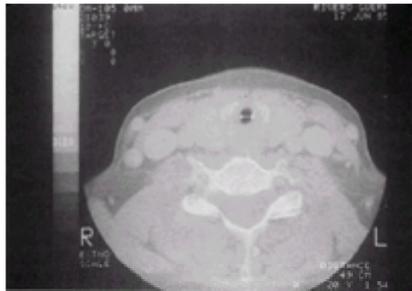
A CT scan showing cartilage destruction and marked narrowing of the trachea. (By courtesy of Dr A. Balsa, La Paz Hospital, Madrid.)
